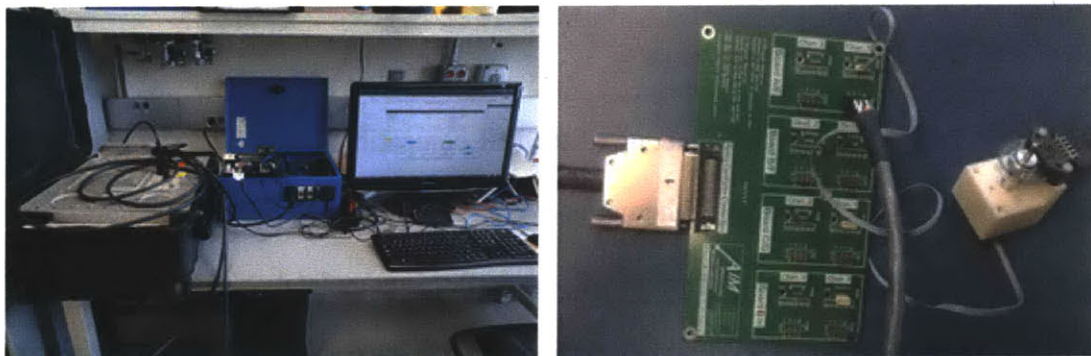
MRI Compatible controller set up and electrical connection to motor. Left: The controller (black box) is equipped to run 5 sets of motor/encoder pairs independently. The interface box (blue) can receive image data from another computer running 3D slicer. It then runs the Java software to convert target points into motor angles and sends command to the controller to actuate the motor and read encoder data. Right: the motors and encoders are plugged into a PCB board that interfaces with the controller.
